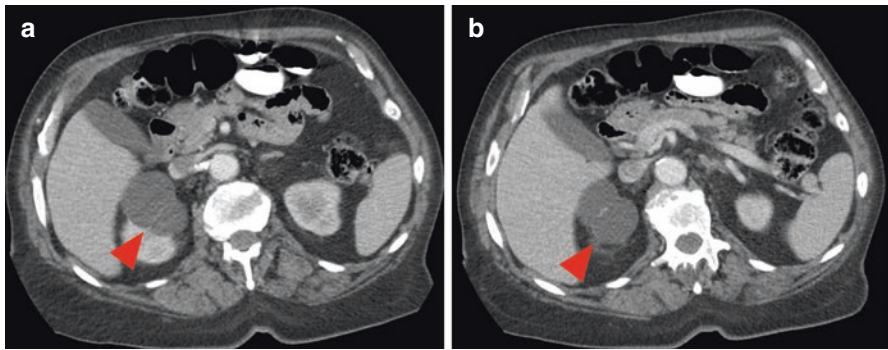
CT images of a Bosniak IIF renal cyst. (a) Axial, venous phase image of a minimally complex right-sided renal cystic lesion. A thin septation (red arrowhead) is apparent within the cystic lesion. (b) On a more superior axial, venous phase image, a smooth thickening of the septation is apparent with visual enhancement, although the septation is too thin to reliably measure this enhancement (red arrowhead)
